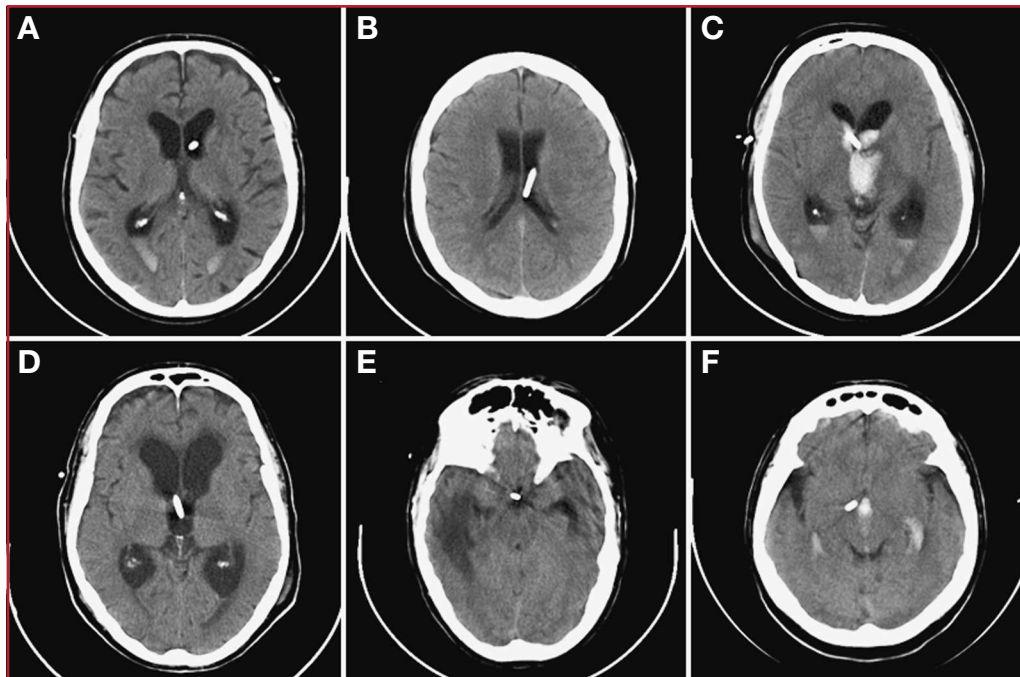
Axial computed tomographic scans showing an external ventricular drain's tip location accuracy: ipsilateral frontal horn (A), body (B), contralateral frontal horn of the lateral ventricle (C), third ventricle (D), basal cisterns (E), and parenchyma (F).
